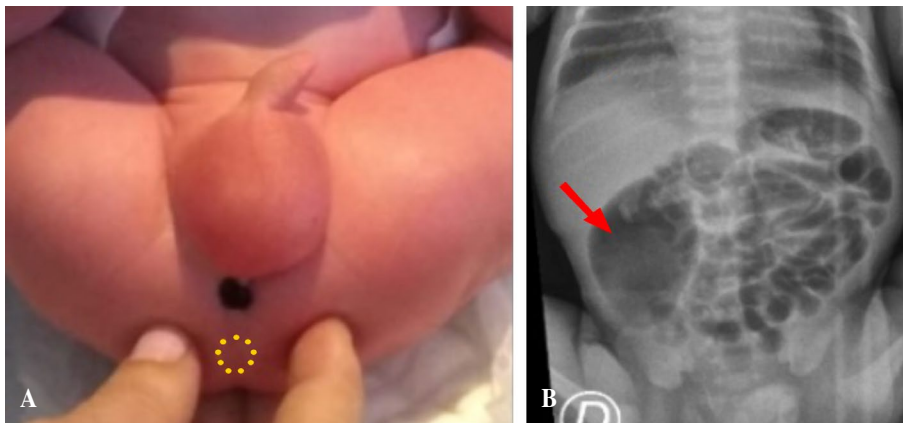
A) Anorectal malformation with perineal fistula. Spontaneous meconium release is observed (the dotted circle marks the site of the theoretical anus; the sit bones are marked with the fingers). B) Abdominal X-ray: aerated cystic mass (arrow).
